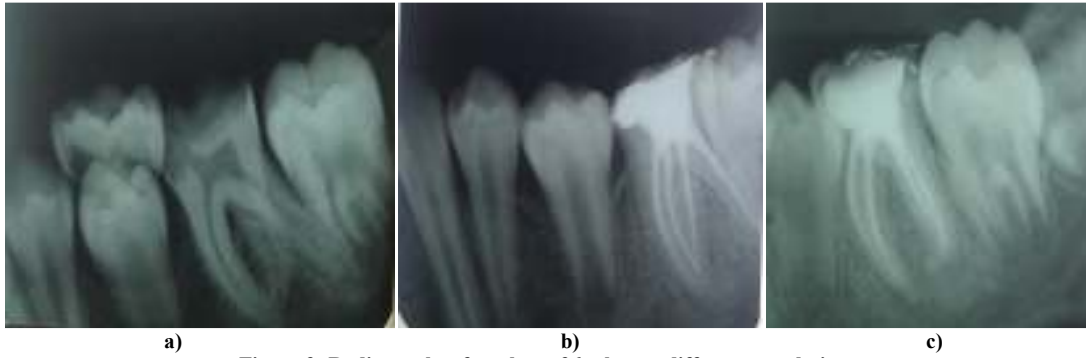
Radiographs of tooth no. 36 taken at different angulations
